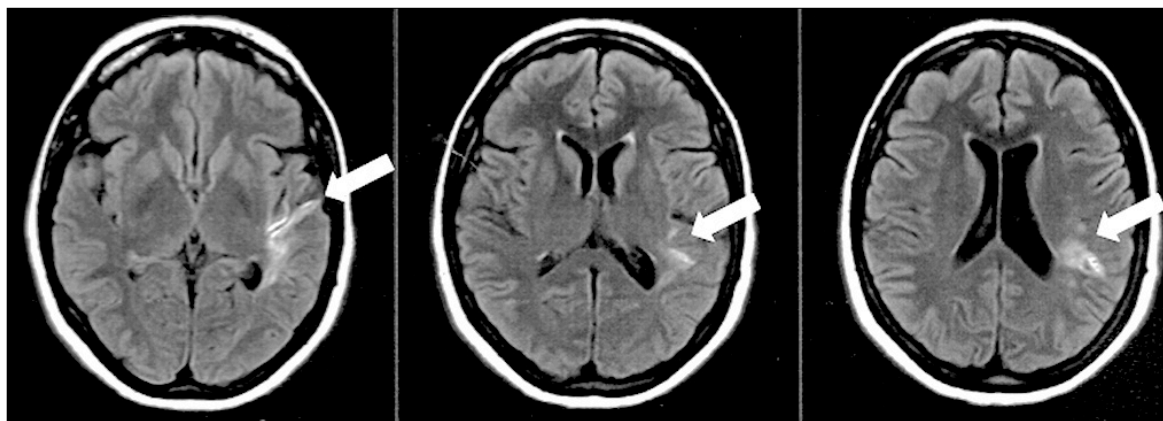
Gadolinium-enhanced T1-weighted cranial magnetic resonance imaging, six months after initial event. Arrows: area of ischemia.
